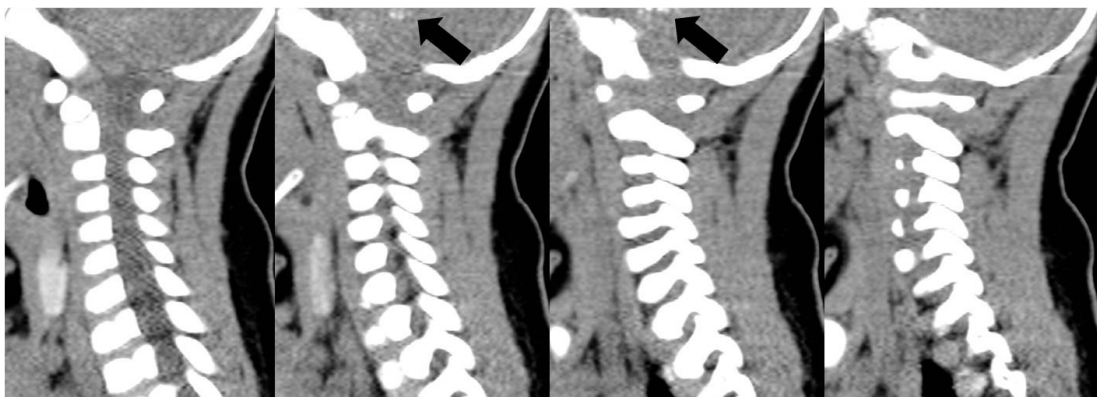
Sagittal source images of cervical spine computed tomography obtained at a different hospital about 4 weeks prior to the emergency department visit. Note the abnormal high-density signals located in the cerebellum (black arrow).
